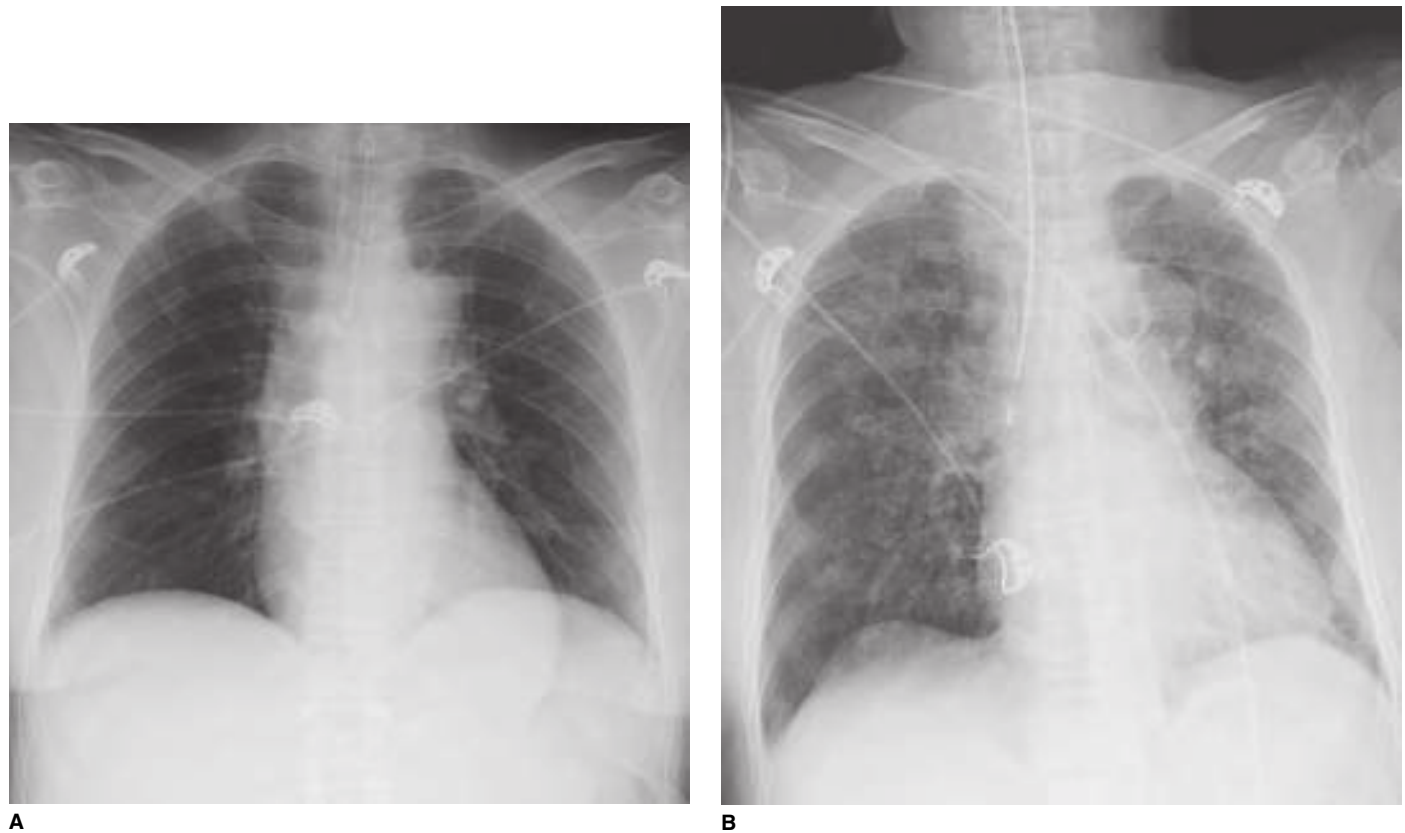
Chest radiographs after intubation. A. The ET tube is in the trachea and above the carina. B. The ET tube is in the right mainstem bronchus.
